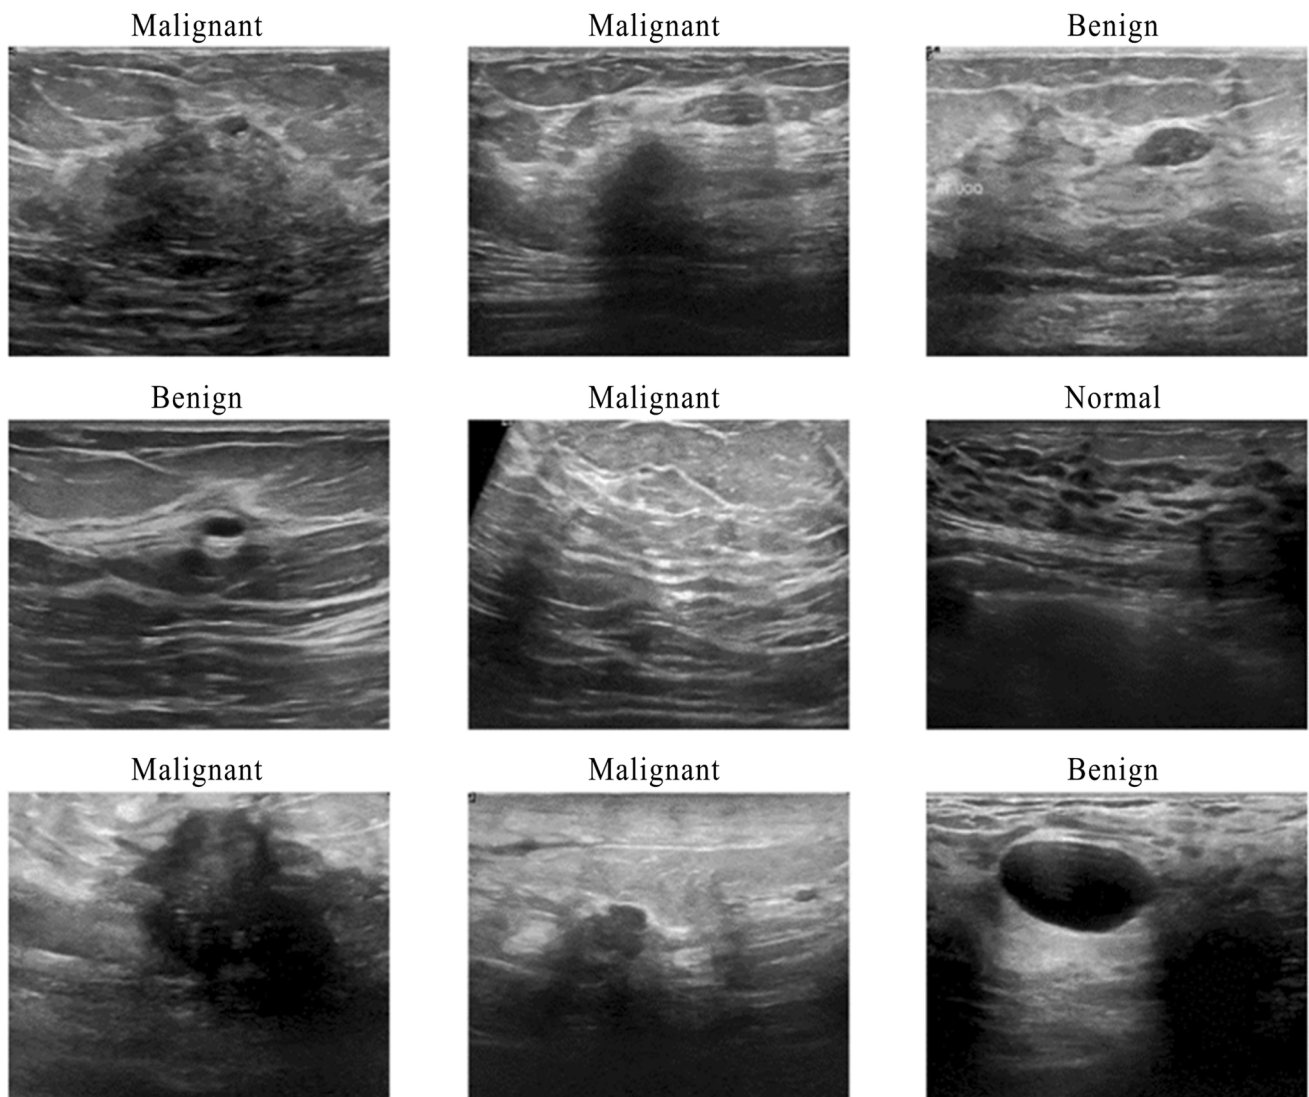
Example breast ultrasound images of the benign, malignant and normal classes in the BUSI dataset
